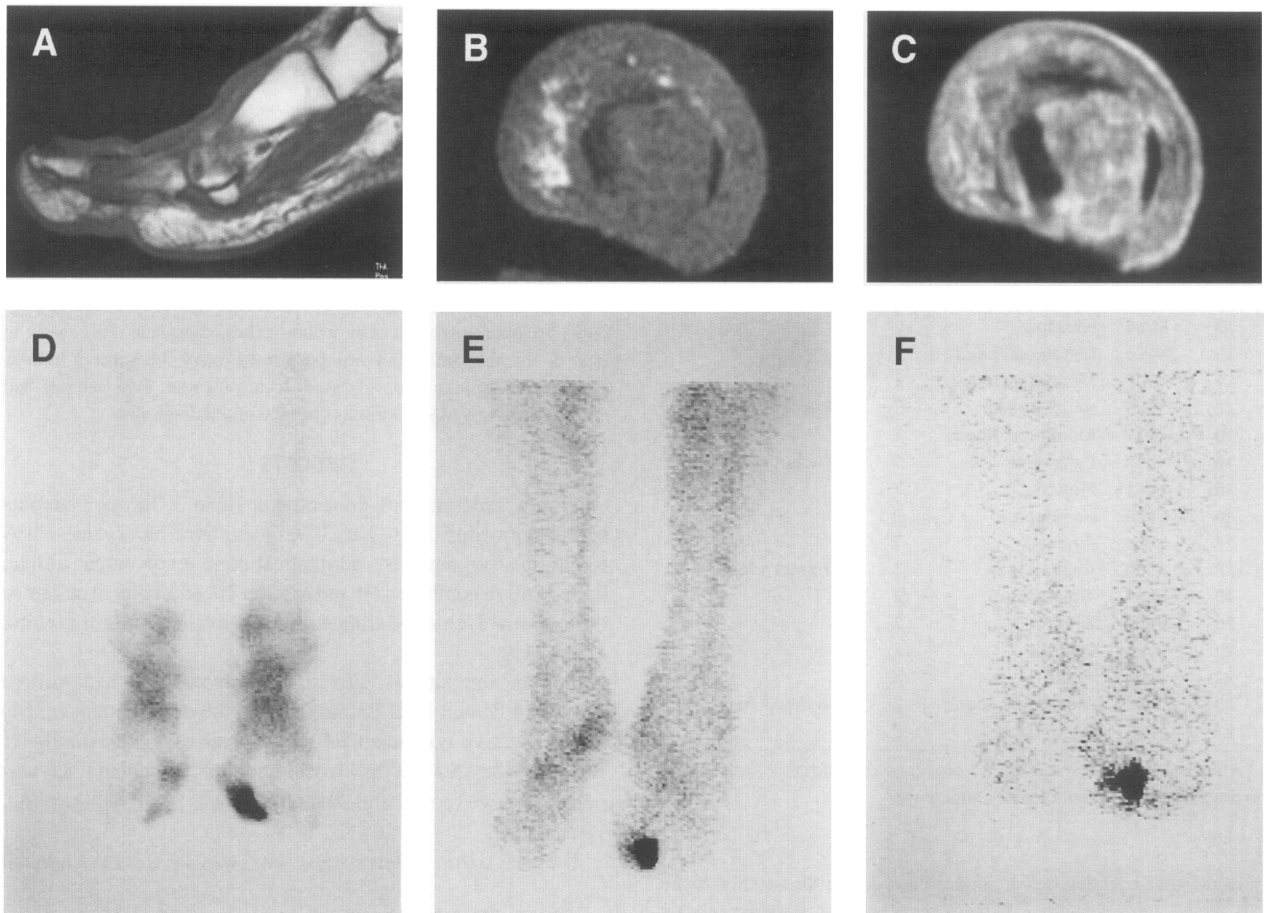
Patient no. 2, a 71-year-old man with a diabetic foot ulcer of the first toe (Wagner 3). (A) Sagittal T1-weighted MRI shows the soft tissue ulcer with decreased enhanced signal of the bone marrow of P1. Axial T1 fat-suppressed images before (B) and after injection of Gd-DOTA (C) show low signal intensity of bone marrow enhancement after injection with cortical interruption and disruption of the cutaneous signal (ulcer). (D) HMDP scan showing increased uptake of the first and second toe. GN scan at 4 hours (E) and 24 hours (F) shows increased uptake in the same area.
